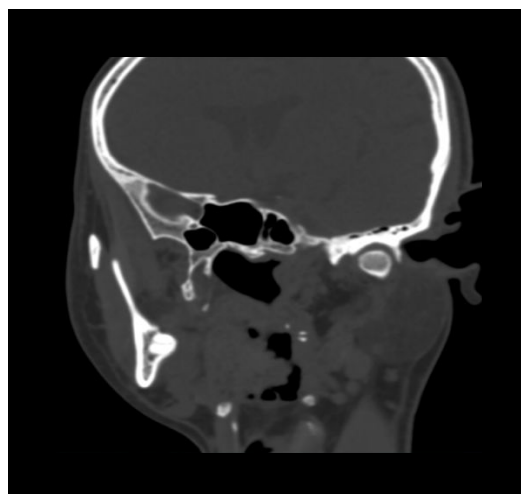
Computed tomography scan of patient (Axial view)
